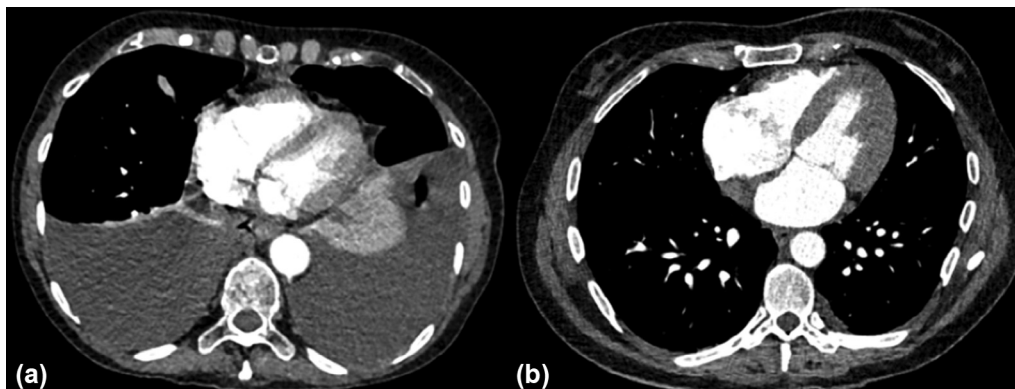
The computed tomography (CT) image in (a) (acquired with the standard pitch CT under breath-hold protocol) shows heart pulsation artifacts, whereas the CT in (b) (acquired with the high-pitch CT under free breathing protocol) is free of motion artifacts.
